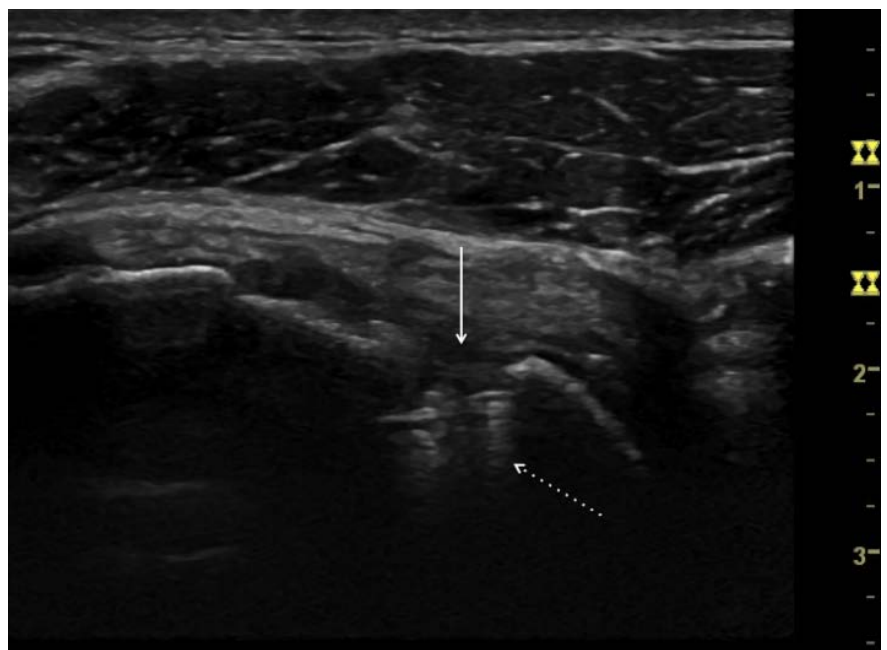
Ultrasound examination 12 months after the repair (transverse scan). The hole drilled on the lesser tubercle (arrow) and the anchor (dashed arrow) is demonstrated.
